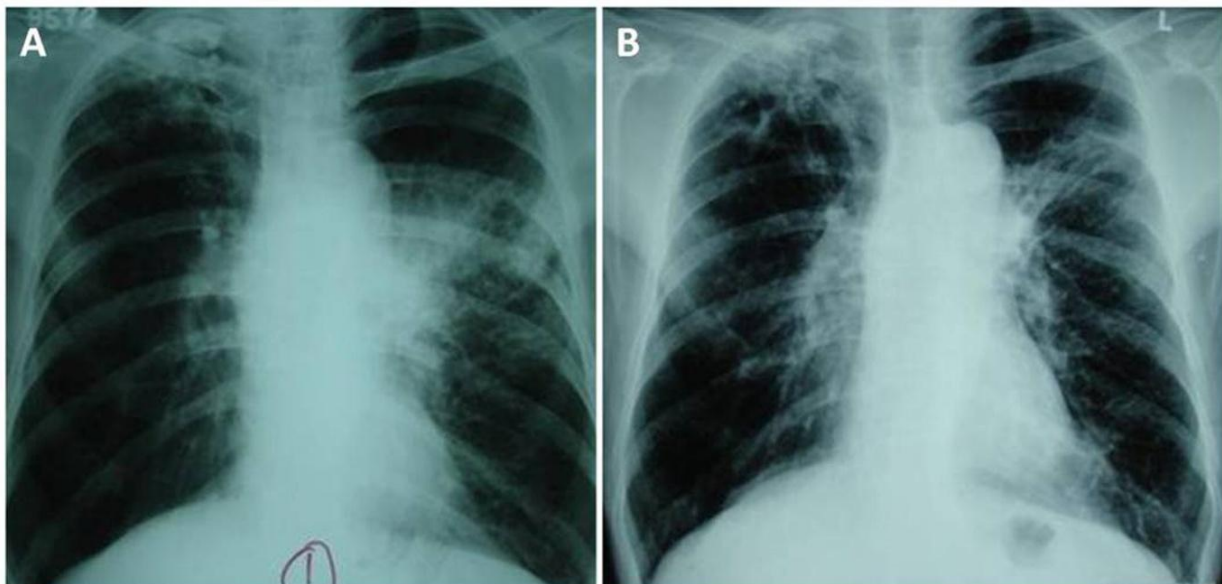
(A) Chest radiograph frontal view shows fibrocalcific opacities in right upper zone and left perihilar and mid zone consolidation. (B) Partial resolution of infiltrates in the left lung with residual fibrosis after treatment
